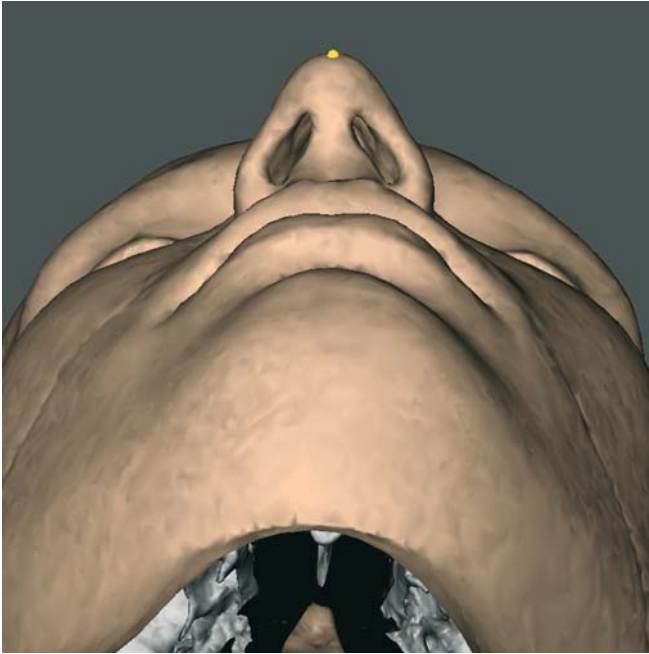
Pronasale. Base view (3-D CT, patient K.C.)
